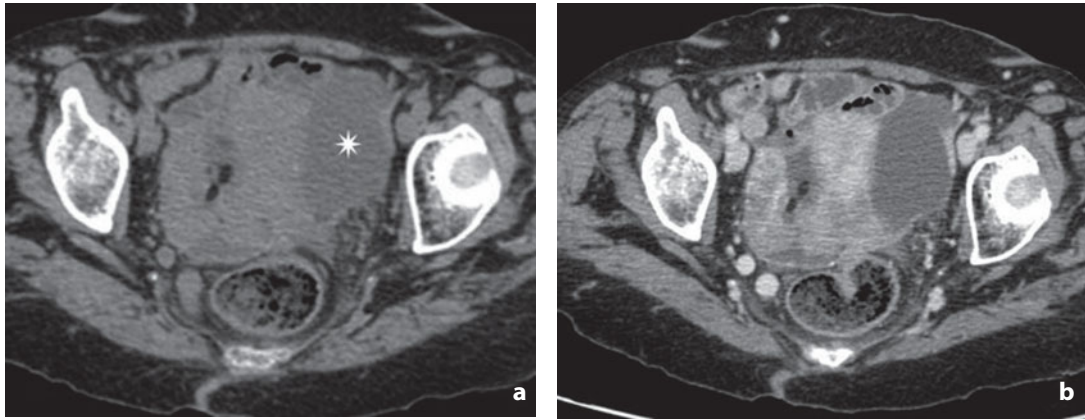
Computed tomography. Peritoneal inclusion cysts. a Image shows an oblong para-uterine mass (*asterisk*) with fluid content and thin walls. After contrast medium administration (b) the lesion displays no wall enhancement and neither septations nor solid nodular components are identifiable
